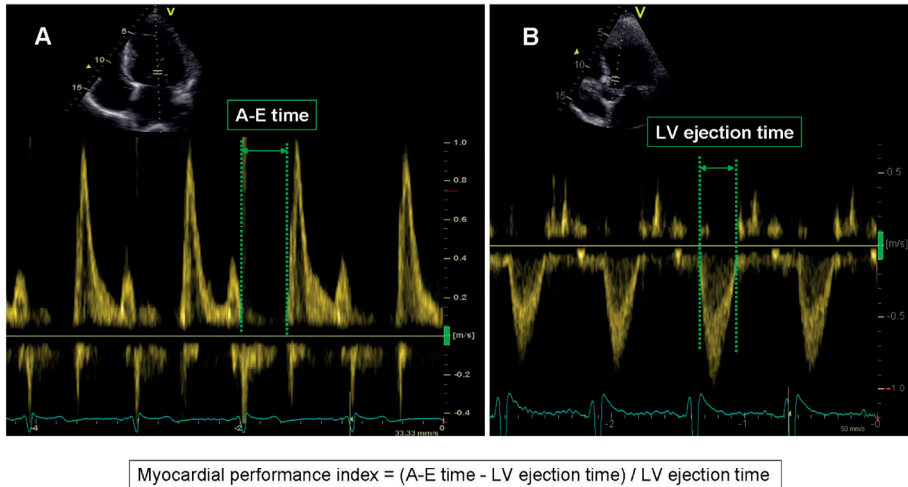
AV interval optimization based on myocardial performance index evaluation. The myocardial performance index is calculated by dividing the sum of the isovolumic relaxation and contraction times by the LV ejection time. The sum of the isovolumic contraction and relaxation times is calculated by measuring the A-E time on pulsed-wave Doppler transmittal inflow recordings (panel A) and the LV ejection time on pulsed-wave Doppler recordings of the LV outflow tract (panel B). Sum of the isovolumic contraction and relaxation times = A-E time – LV ejection time.
